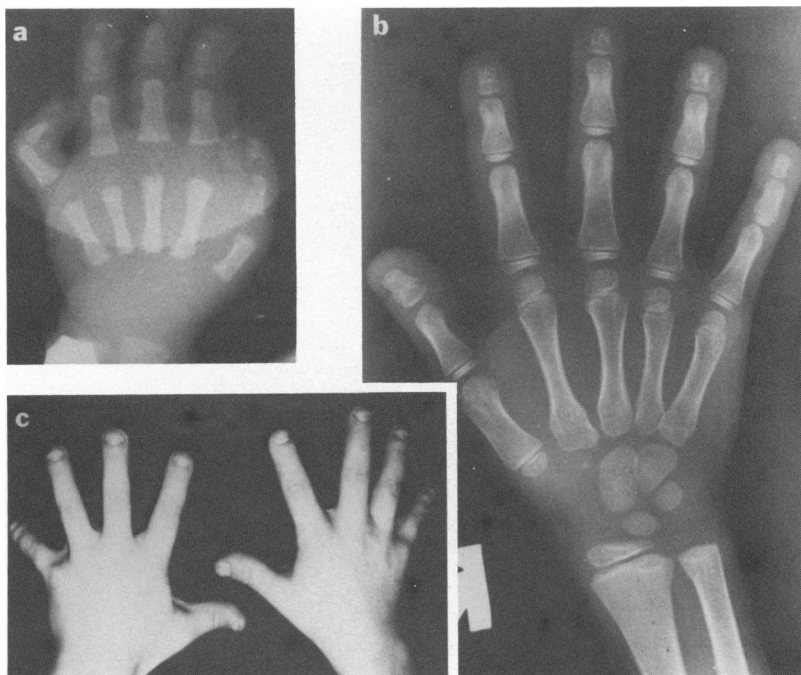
a*, Hand radiograph in the first day of life, showing decreased development of the distal phalanges. *b*, Hand radiograph at 7½ years, showing persistence of distal digital hypoplasia. *c*, Photograph of hands at 7½ years showing generalized brachydactyly, which parallels the radiographic features.
